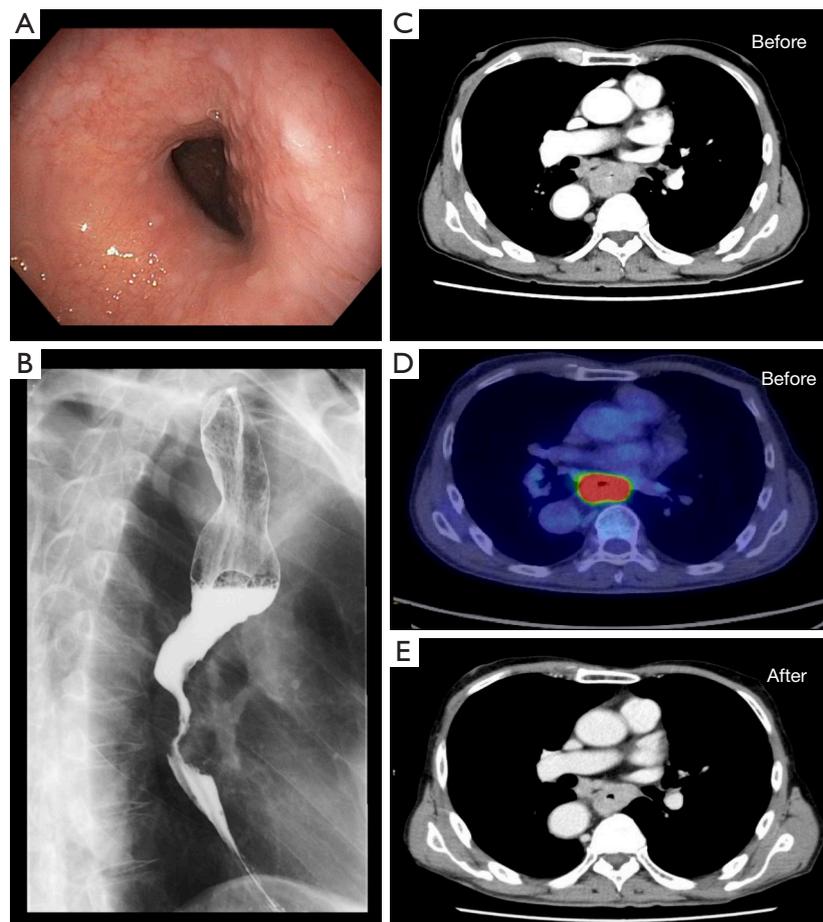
Preoperative Image. (A) Endoscopic findings show a type II tumor surrounding the wall in the middle thoracic esophagus; (B) barium esophagography show the narrowing of the middle and lower mediastinum; (C-E) enhanced computed tomography (CT) and positron emission tomography CT-showing esophageal cancer before neoadjuvant chemotherapy and then shrinking of the esophageal cancer lesion after chemotherapy.
